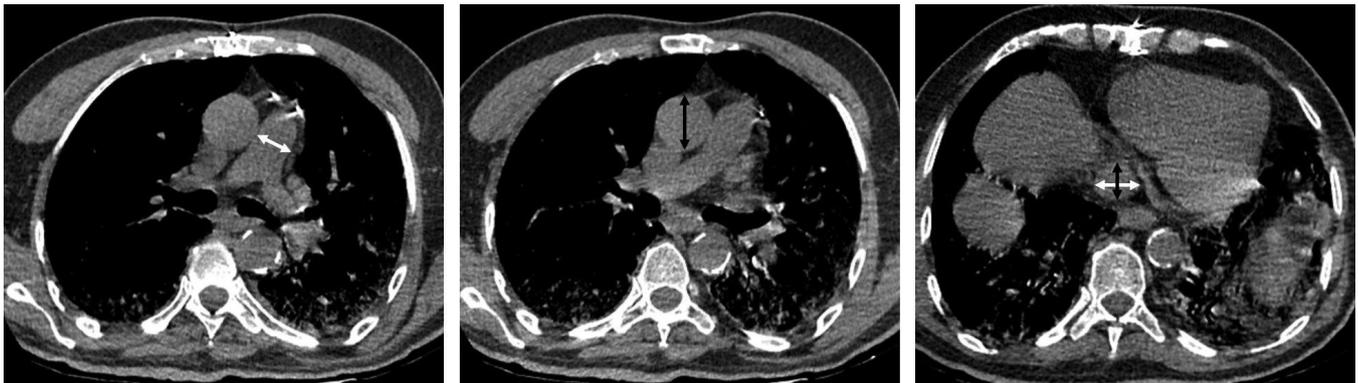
PA to A ratio was calculated from the axial CT slice by dividing the diameter of PA measured at the level of the PA bifurcation (white arrow) (A) by ascending aortic diameter measured at the level of right pulmonary artery (black arrow) (B). The average diameters of IVC were measured at the level of the right diaphragmatic crus by dividing the maximum transverse diameters of IVC (white arrow) by maximum anteroposterior diameters (black arrow) (C). PA: Pulmonary artery, CT: computed tomography, IVC: inferior vena cava
